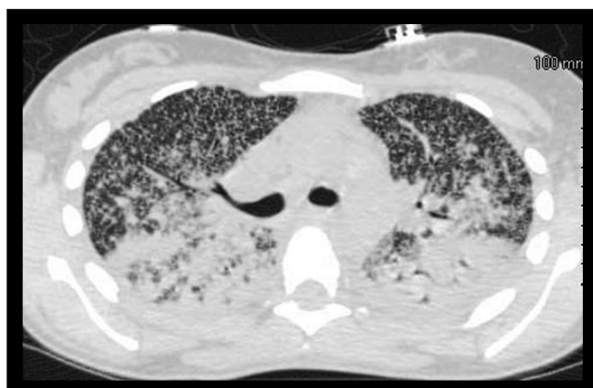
CT chest at presentation showing reticular nodular interstitial pattern throughout both lungs.
